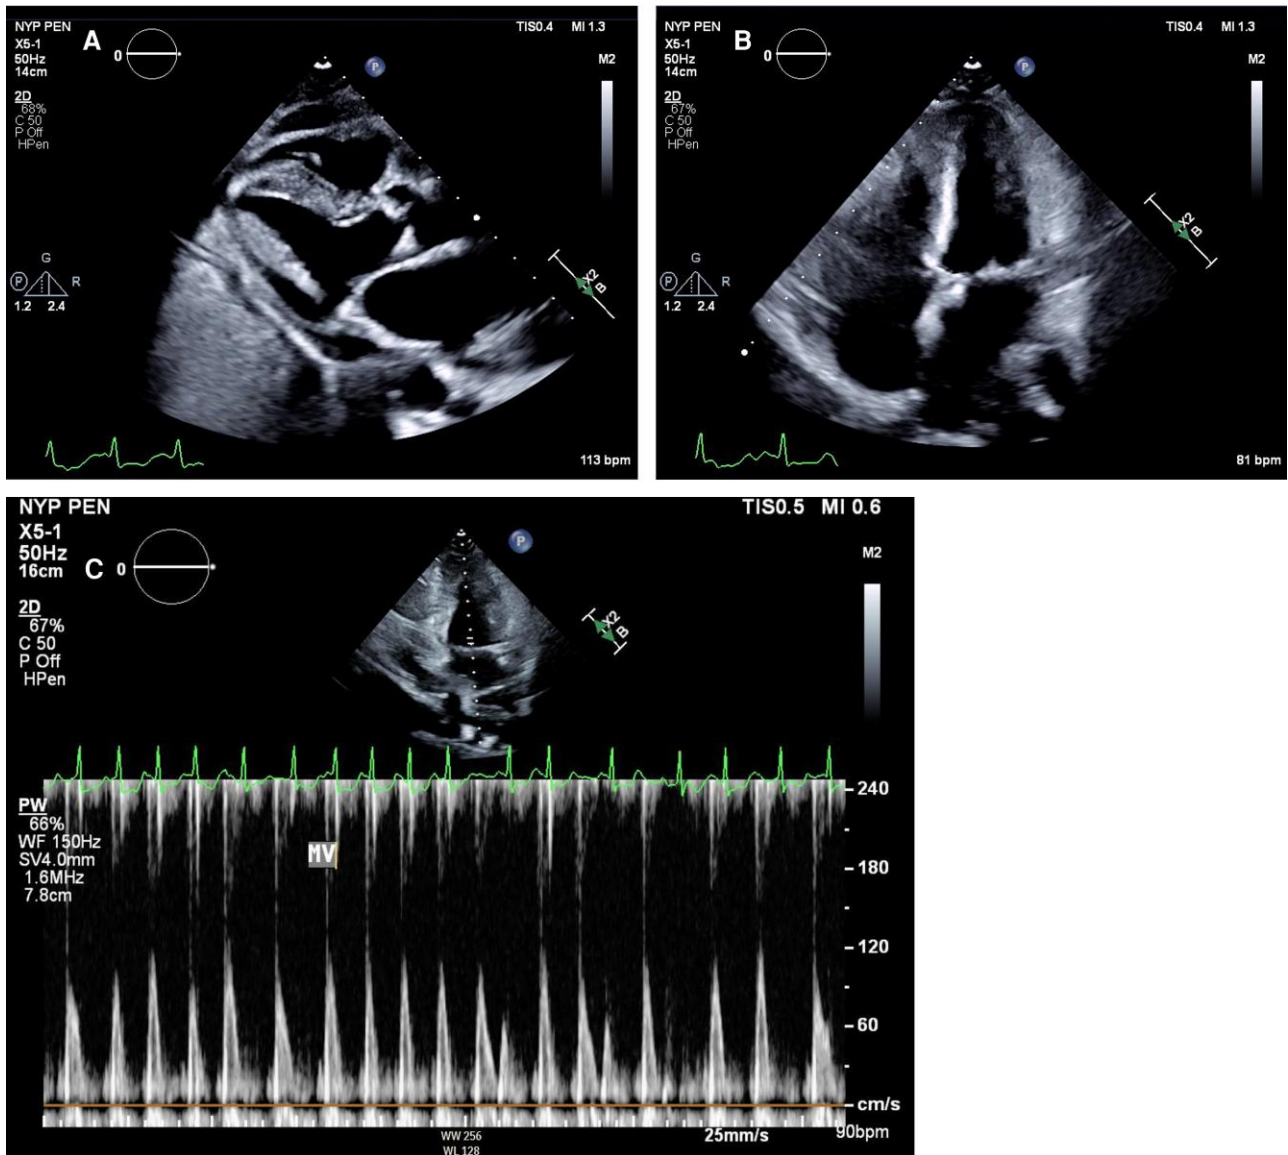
Transthoracic echocardiogram. (A) Parasternal long-axis view showing normal left ventricle function and small localized pericardial effusion posterior to the left ventricle. Pericardial thickening measuring up to 0.8 cm anterior to the right ventricle. Septal flattening suggesting right ventricular overload. (B) Four-chamber view showing a septal bounce in some views. See videos in [Supplementary material online, Files](#). (C) Transmitral diastolic velocities showing marked respirophasic variation consistent with constrictive physiology.
